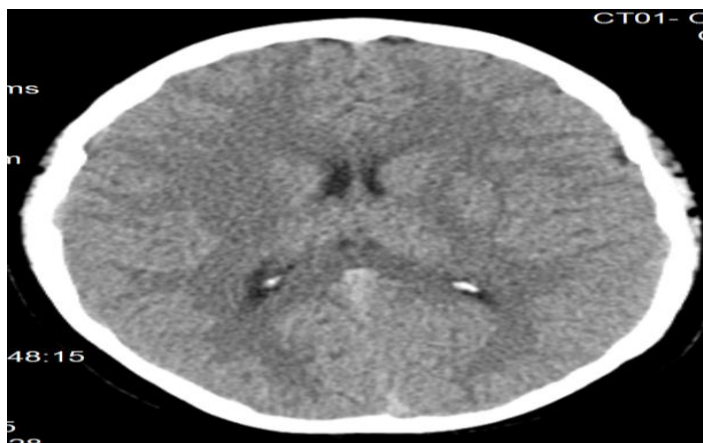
Cerebral computed tomography (CT) of the patient's brain showing no edema or hemorrhage.
